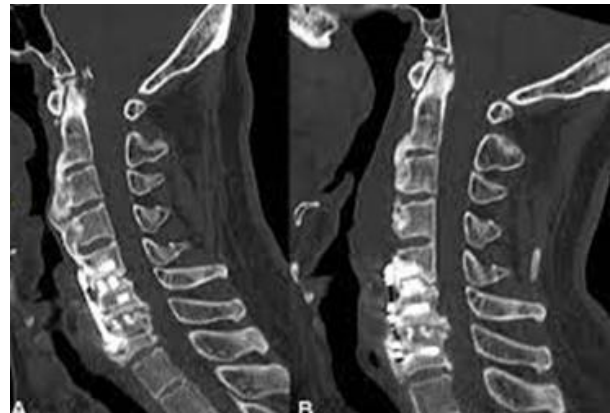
CT scan of a patients showing anterior longitudinal ligament ossification
